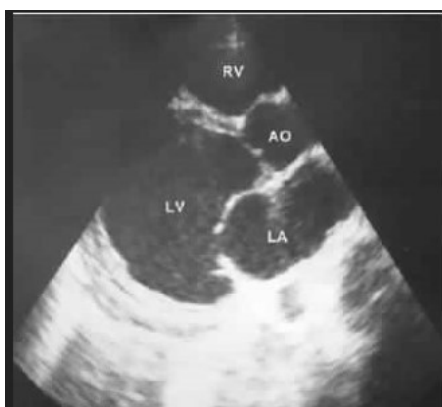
Transthoracic echocardiography showing dilated left atria and ventricle
